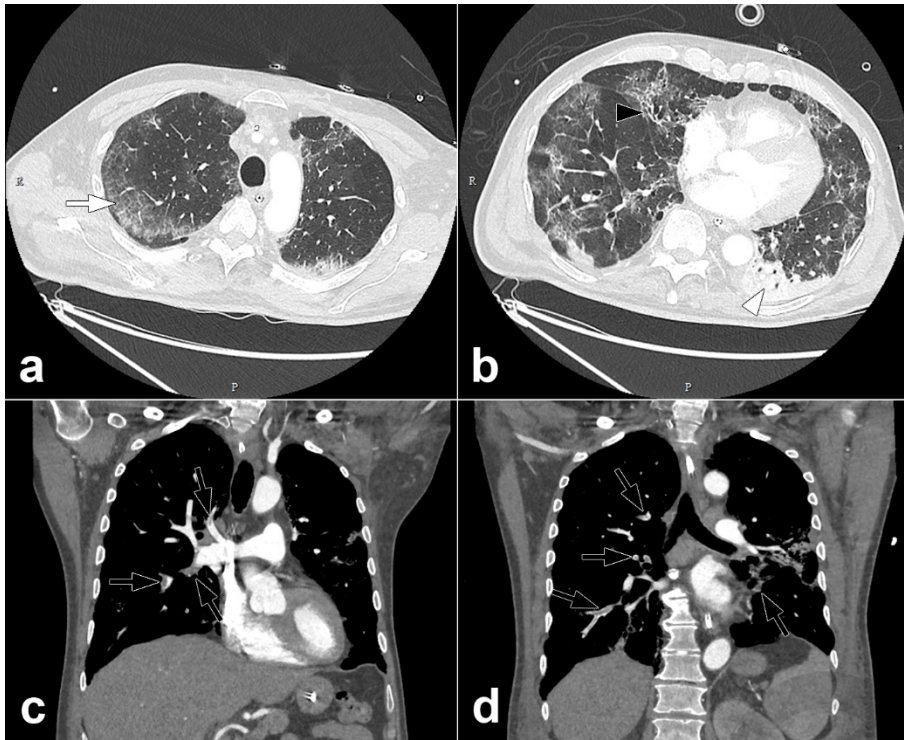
Pulmonary CT angiography of a 68 year old male. The CT scan was obtained 10 days after the onset of COVID-19 symptoms and on the day the patient was transferred to the intensive care unit. Axial CT images (lung windows) (a,b) show peripheral ground-glass opacities (arrow) associated with areas of consolidation in dependent portions of the lung (arrowheads). Interlobular reticulations, bronchiectasis (black arrow) and lung architectural distortion are present. Involvement of the lung volume was estimated to be between 25% and 50%. Coronal CT reformations (mediastinum windows) (c,d) show bilateral lobar and segmental pulmonary embolism (black arrows).
